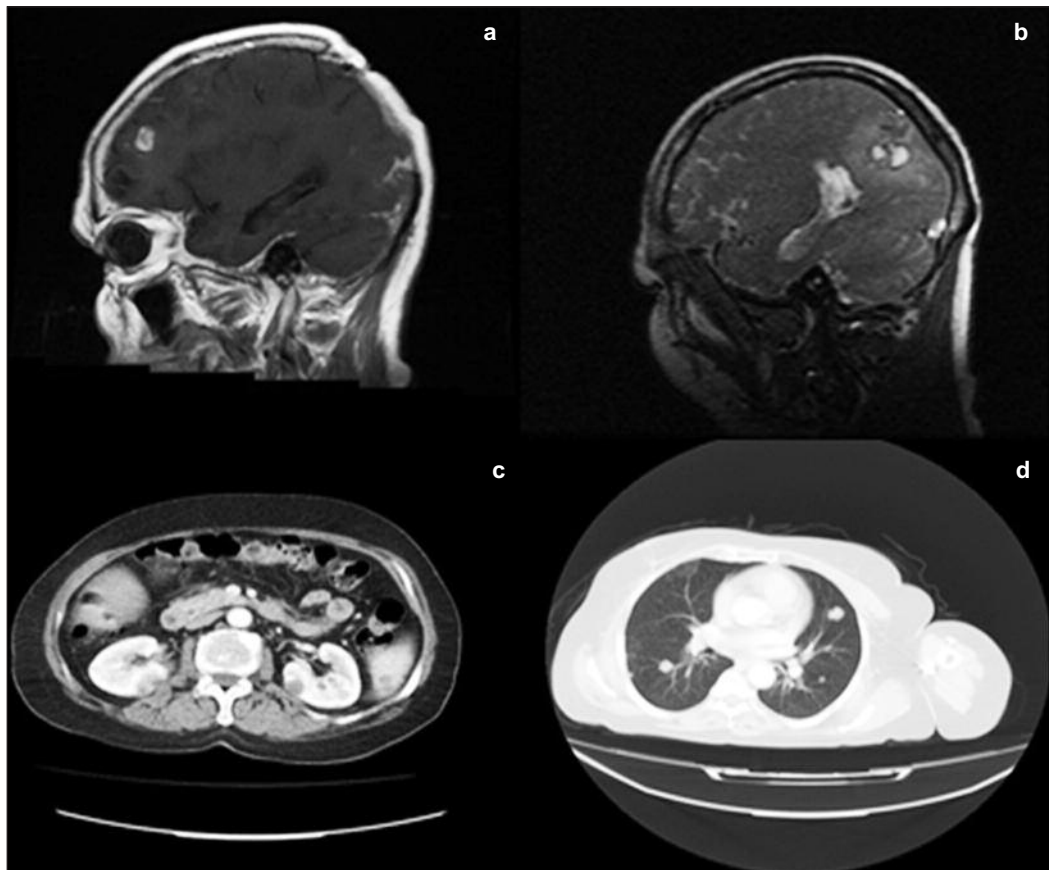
Hyperintense metastatic lesions in frontal, temporal and parietal lobes of the brain in magnetic resonance imaging (a, b) and the appearance of liver, lung and spleen metastases in computed tomography imaging (c, d).
